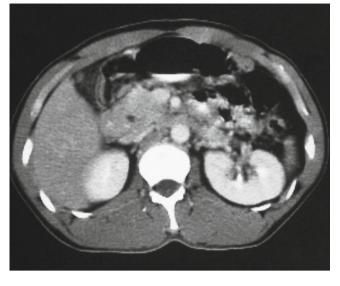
Abdominal CT 2-cm-diameter lymph nodes are seen on the lesser curvature of the stomach side and ventral side of the common hepatic artery. 1.5×3 -cm lymph node swelling is also seen in the posterior pancreatic head. No masses were seen in the pancreas, and the pancreatic duct was not dilated
